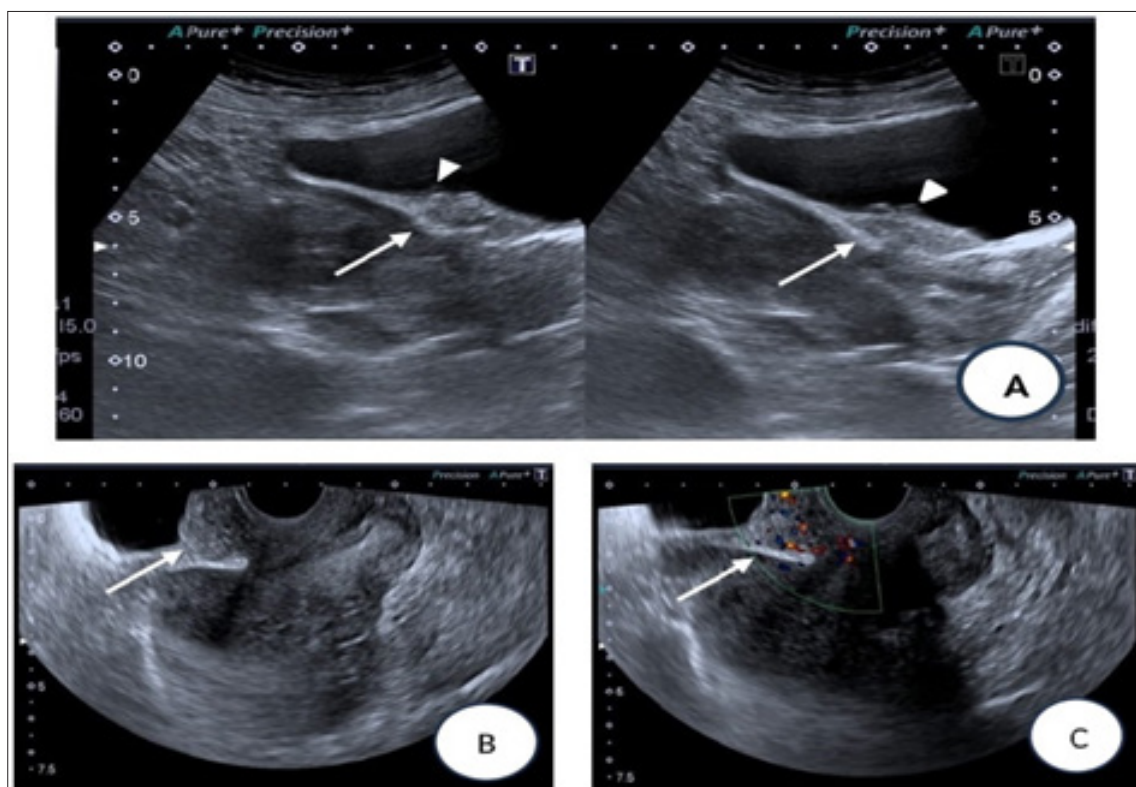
Transabdominal (A) and Transvaginal (B) Ultrasound images showing heterogeneous echogenicity soft tissue thickening along the posterior urinary bladder wall (white arrow) with few small cystic areas (white arrow heads). It was inseparable from the anterior uterine wall. Doppler evaluation (C) revealed moderate flow within the lesion.
